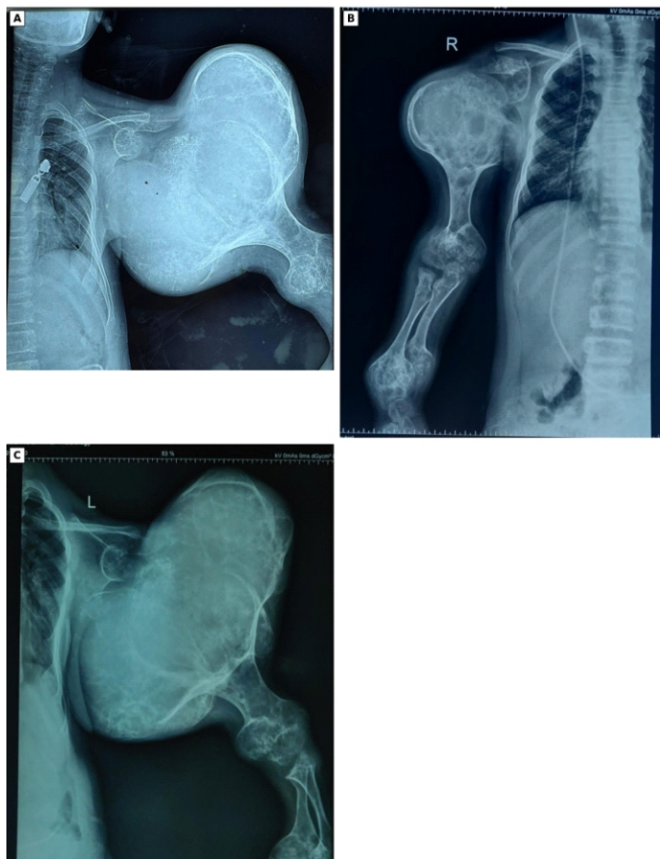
Interval radiographs of the giant proximal humeral lesion. (a and b) Radiograph of left and right shoulder, respectively, showing a large expansile chondroid lesion with proximal humeral deformity. (c) One-year follow-up interval radiograph demonstrating persistent massive enlargement and no increase in size.
